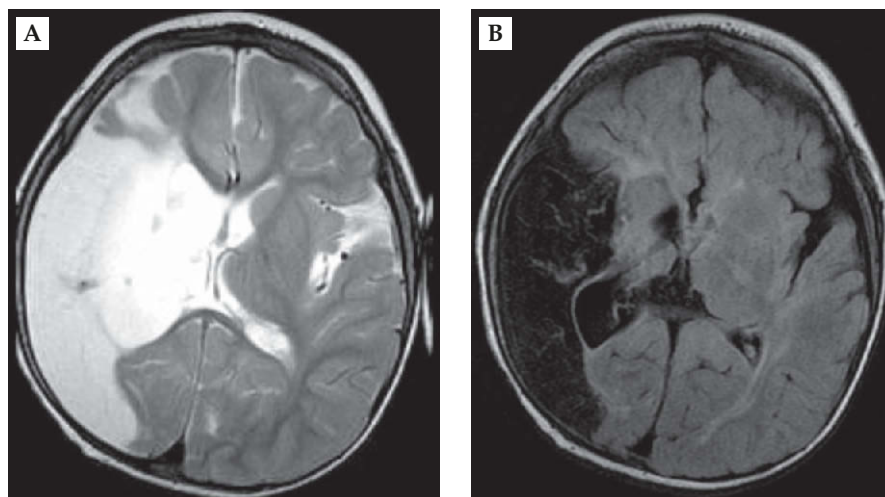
Magnetic resonance image of the patients at the age 1 year and 7 months. (A) T2-weighted image and (B) T2 FLAIR demonstrated encephalomalacia in the right middle cerebral artery territory and left frontal lobe.
